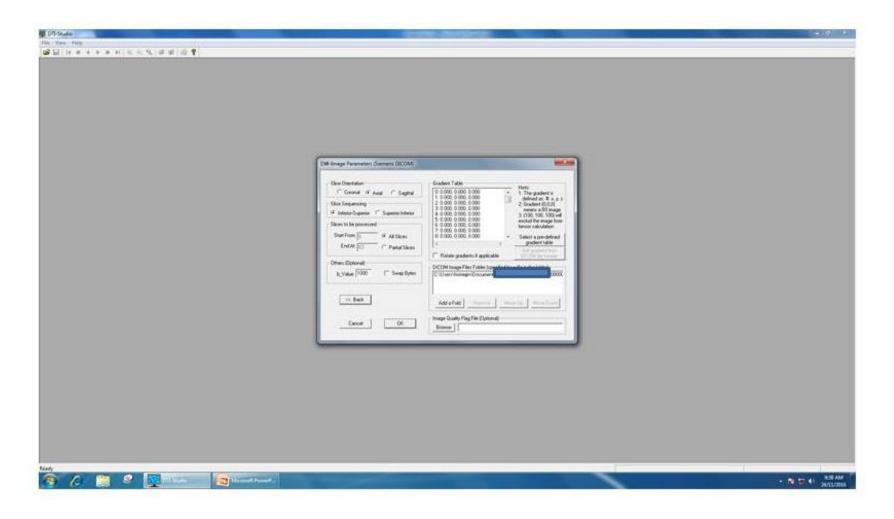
The DWI Image Parameters interface.
